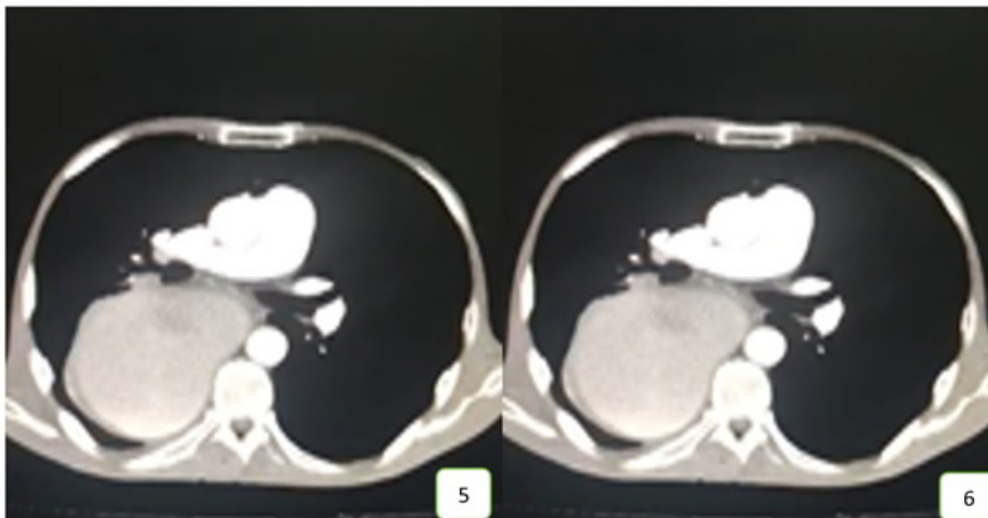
CT-scan of the chest show cystic and solid lesion with air fluid level and compress the trachea and carina
